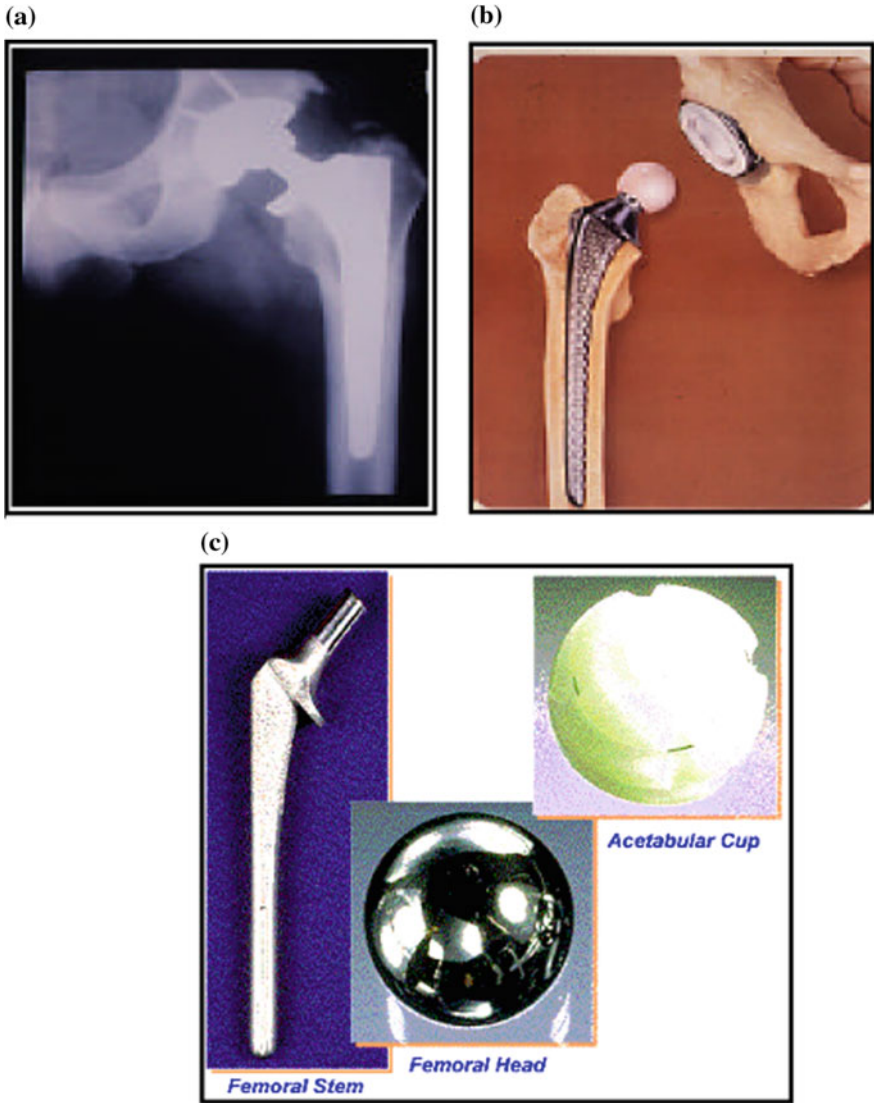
An X-ray showing the natural hip joint (a); assembly of an artificial hip joint using biomaterials (b) and components of a total hip replacement (c) [45]
